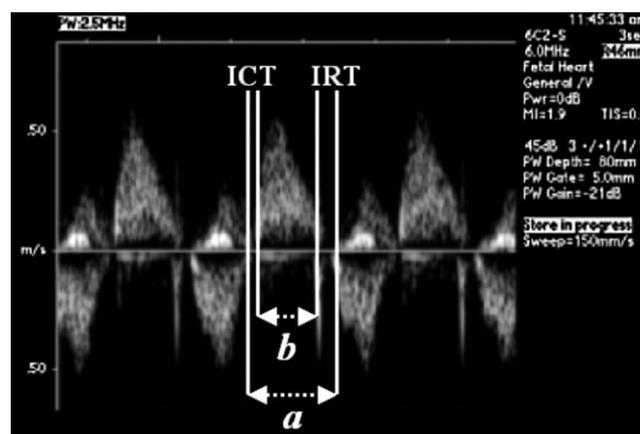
Left ventricular Tei index measurement using pulsed-wave Doppler-derived blood flow velocity waveforms obtained simultaneously from the mitral and aortic valves. a , time interval from closure to opening of the mitral valve; b , time interval from opening to closure of the aortic valve (ejection time). ICT, isovolumic contraction time; IRT, isovolumic relaxation time; Tei index = $(a - b)/b$.
